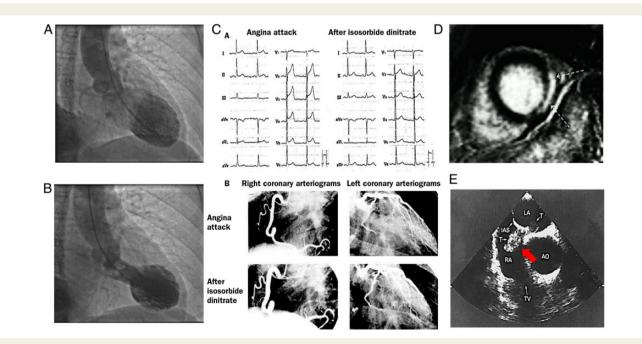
Microvascular causes of myocardial infarction with no obstructive coronary atherosclerosis. (*A* and *B*) Takotsubo syndrome during diastole (*A*) and systole (*B*). (*C*) Spontaneous ST segment elevation and angina in the absence of epicardial spasm relieved by nitrate administration in a patient with coronary microvascular spasm. (*D*) Late gadolinium-enhanced (LGE) imaging in a patient with myocarditis; typical pattern of hyper-enhanced areas (dotted arrows), suggesting fibrotic tissue in the mid-inferolateral segments in short-axis orientation. (*E*) Thrombus (red arrow) in transit through a patent foramen ovale at two-dimensional transoesophageal echocardiography. (Ao, aorta; TV, tricuspid valve; LA, left atrium; RA, right atrium).
